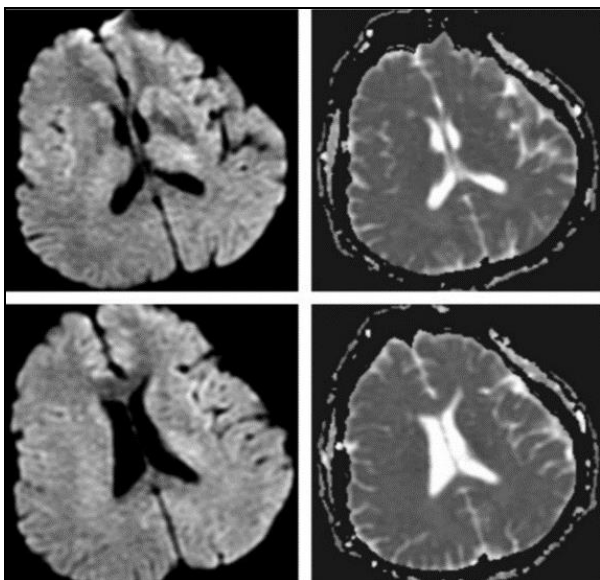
DWI and ADC imaging of the patient taken 48 hours later (Hyperintense lesions have disappeared).
